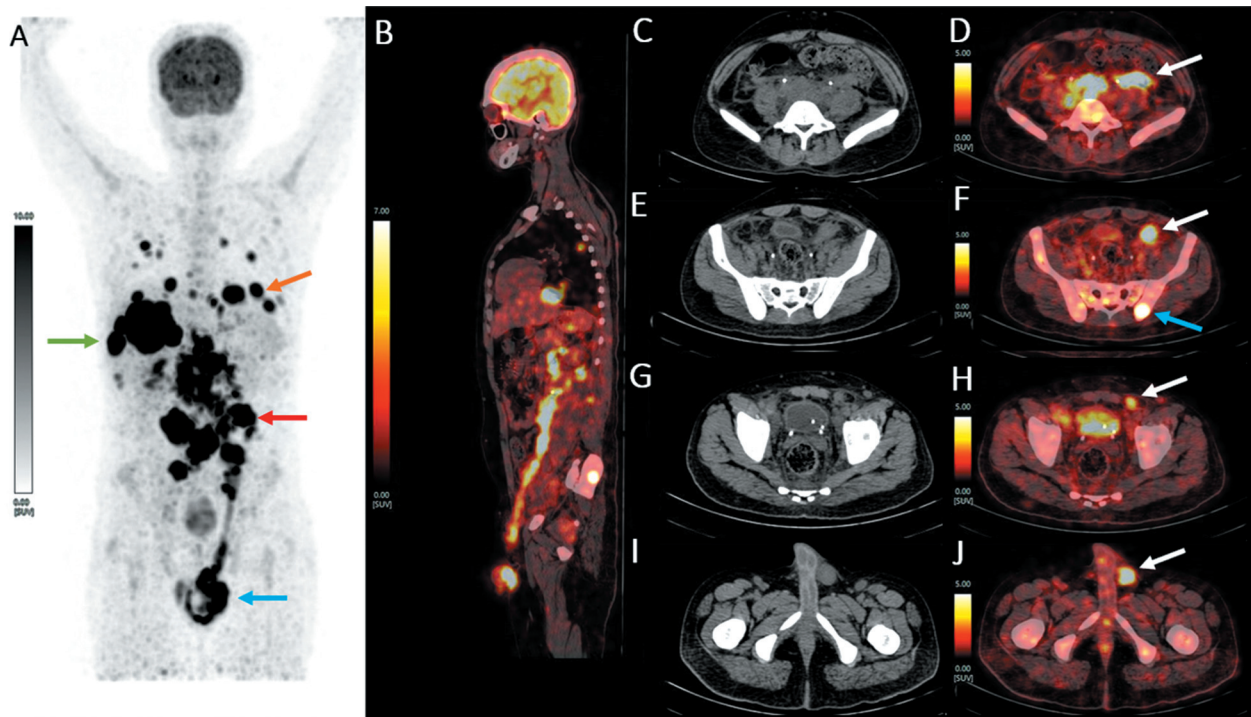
[¹⁸F]FDG-PET/CT maximum intensity projection (MIP) demonstrating low brain uptake relative to the primary testicular lesion (blue arrow) as well as metastatic sites like retroperitoneal lymph nodes (red arrow), hepatic metastasis (green arrow), and pulmonary nodules [orange arrow] (A). Fused sagittal view showing linear [¹⁸F]FDG avidity along the entire lymphatic path of metastasis from the left testis to the para-aortic lymph nodes (B). CT and fused images showing metabolically active metastatic lesions—para-aortic lymph nodes (C, D), enlarged lymph nodes along the left testicular vein (white arrow), and wing of left ilium (blue arrow) (E, F), thickened left spermatic cord at the level of internal inguinal ring (G, H) and thickened, bulky left epididymis (I, J). [¹⁸F]FDG-PET/CT, [¹⁸F]-fluorodeoxyglucose positron emission tomography/computed tomography.
